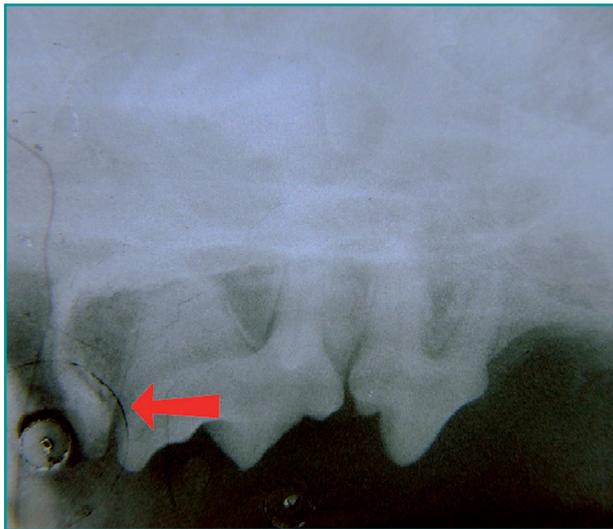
Radiograph of the right upper dental arch: vertical alveolar bone loss between the distal root of the last premolar and the first molar (arrow).
